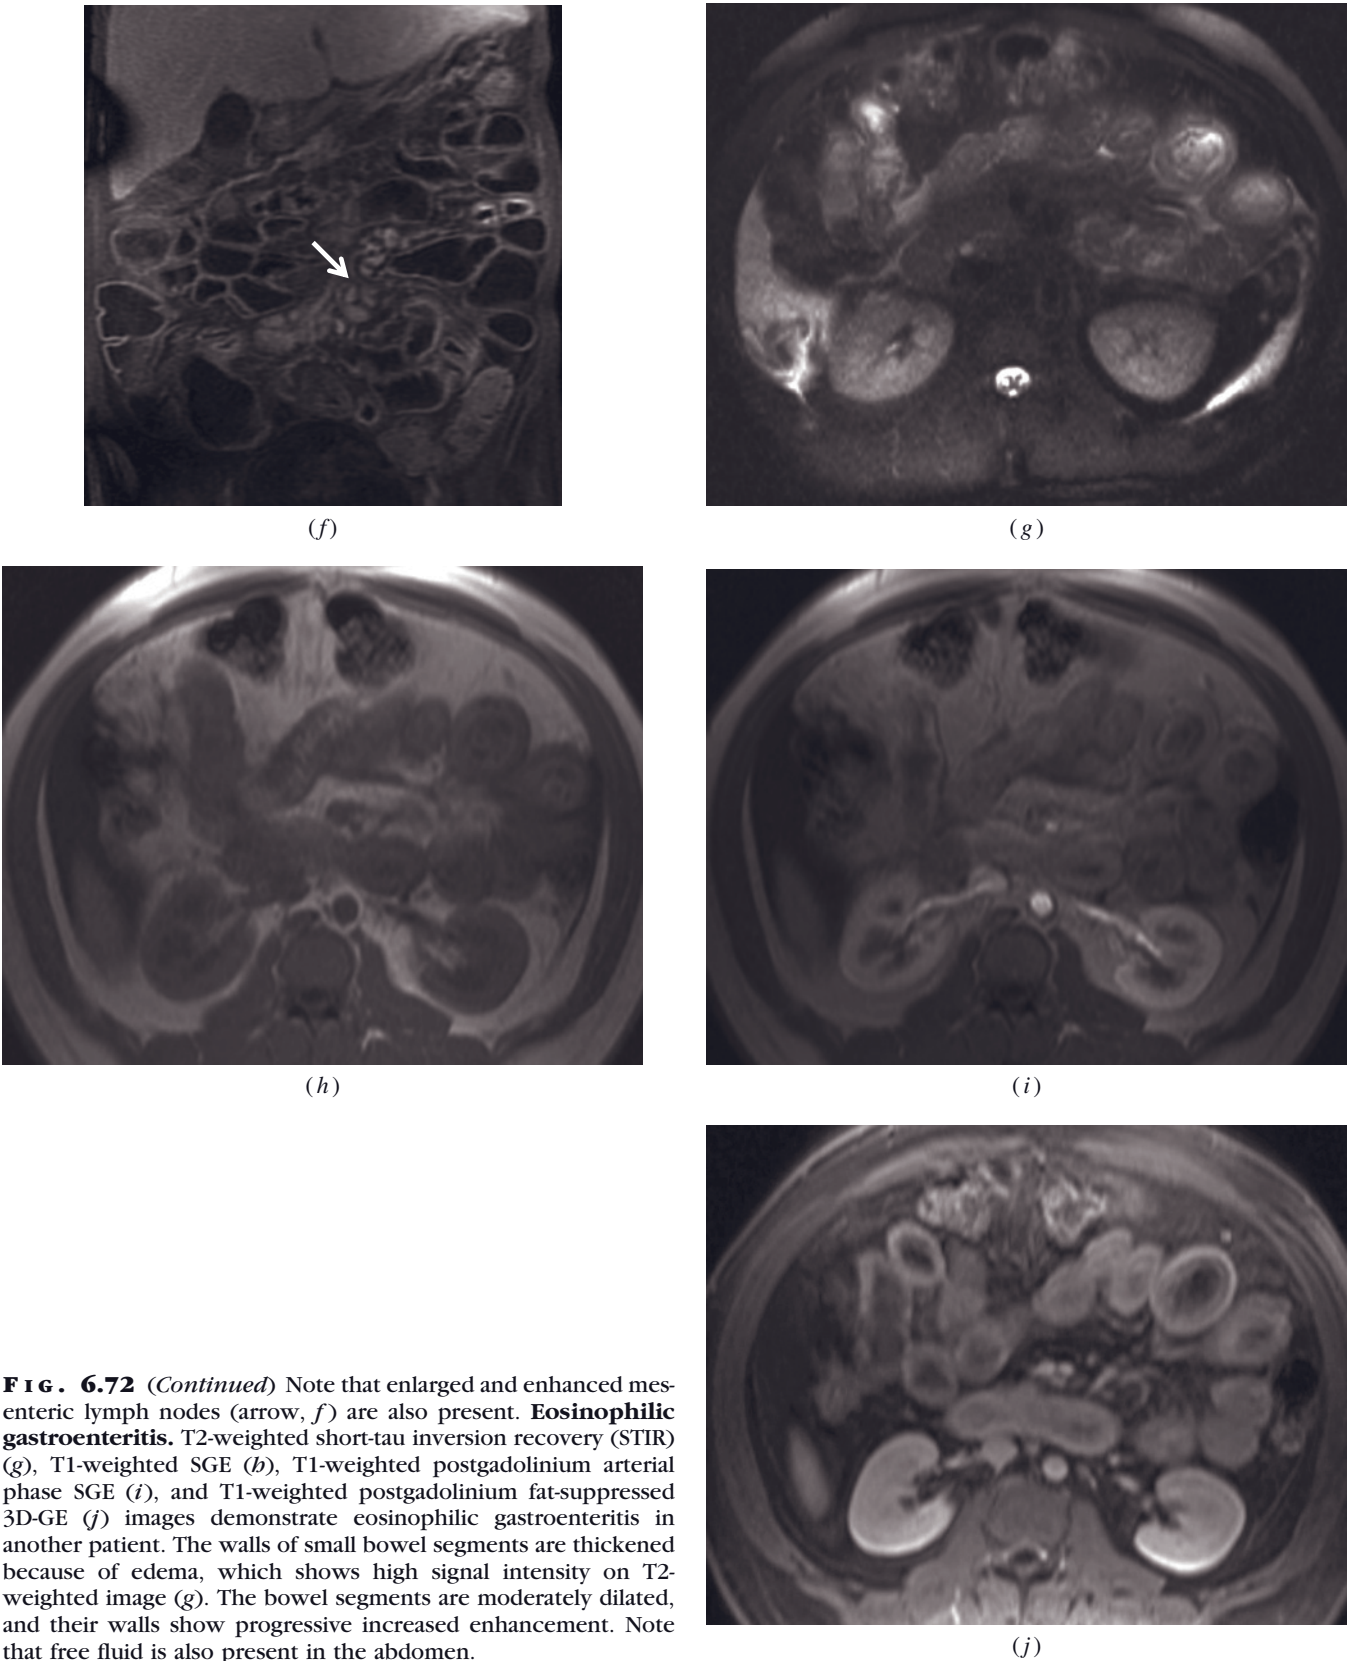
(*Continued*) Note that enlarged and enhanced mesenteric lymph nodes (arrow, *f*) are also present. Eosinophilic gastroenteritis. T2-weighted short-tau inversion recovery (STIR) (*g*), T1-weighted SGE (*h*), T1-weighted postgadolinium arterial phase SGE (*i*), and T1-weighted postgadolinium fat-suppressed 3D-GE (*j*) images demonstrate eosinophilic gastroenteritis in another patient. The walls of small bowel segments are thickened because of edema, which shows high signal intensity on T2-weighted image (*g*). The bowel segments are moderately dilated, and their walls show progressive increased enhancement. Note that free fluid is also present in the abdomen.
